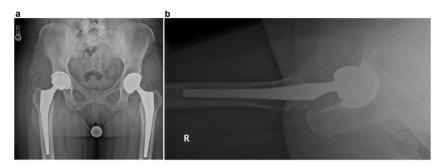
Postoperative (a) anteroposterior and (b) lateral radiographs of the right hip demonstrating appropriate placement of components without evidence of complication.
